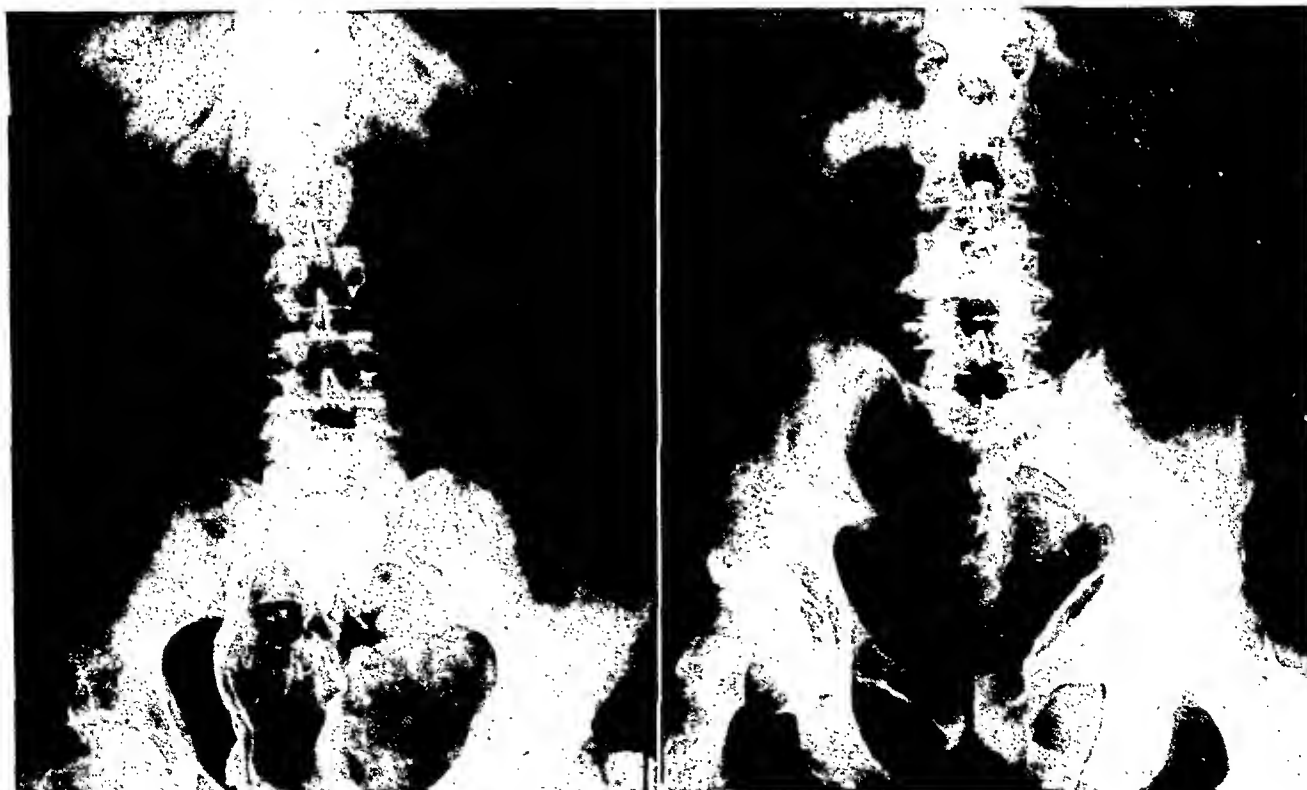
X-ray shows tantalum in place in upper abdomen.
